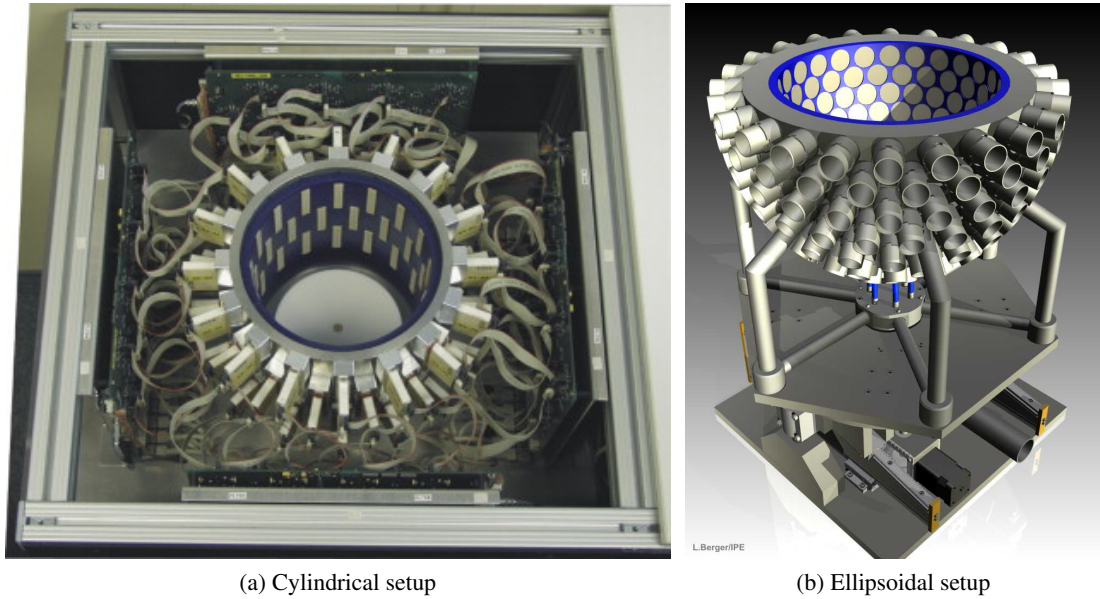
Two experimental 3D ultrasound computer tomography setups used for breast-cancer examinations: (a) Cylindrical configuration with 48 transducer arrays (32 receivers and 8 emitters each) [10], (b) Rotation symmetrical ellipsoid configuration with 157 cylindrical transducer arrays (9 receivers and 4 emitter each) [12].
